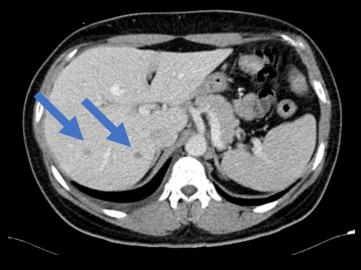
Focal Nodule. Axial CT scans (without contrast, portal phase, delayed phase). The lesions or only seen in portal phase, as hypodense focal lesion.
